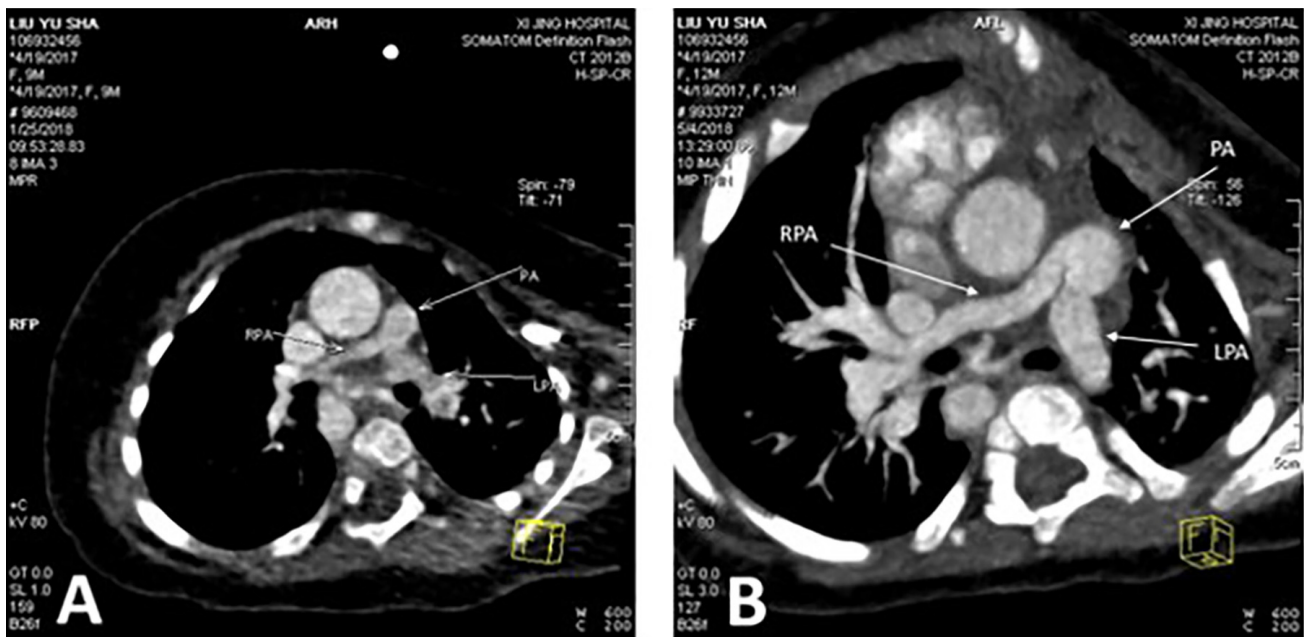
CT image of a 9-month-old female TOF patient. (A) CT image before the mTAP procedure (McGoan ratio: 1.08). (B) CT image before complete surgical repair (3 months after the mTAP procedure, McGoan ratio: 1.87). CT, computed tomography; TOF, tetralogy of Fallot.
